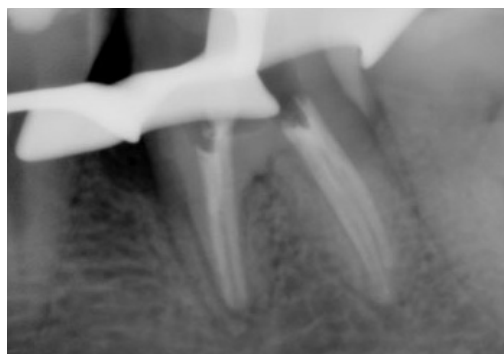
Periapical Radiograph for Determination of Working Length Showing Three Roots and Six Canals.
